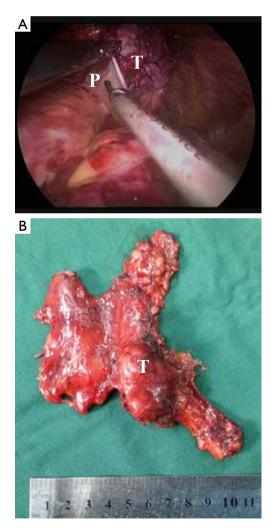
The thymoma invading the pericardium (Case No. 1): (A) the invaded pericardium could be resected by the ultrasonic scalpel; (B) the sample after operation. P, pericardium; T, tumor.
